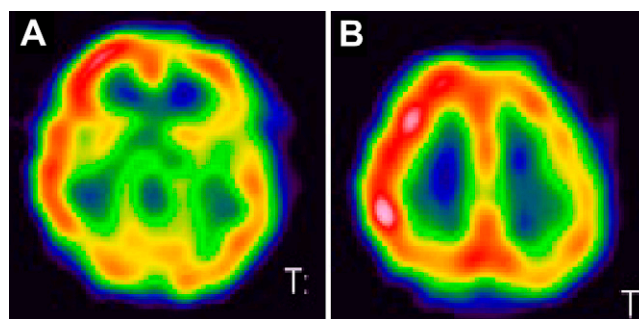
The neurological symptoms of motor aphasia and left upper limb paresis persisted to POD 8 and then started to improve. SPECT on POD 10 shows improvement of the CBF of the left MCA territory. A: Ventricular level. B: Centrum Semiovale level.
